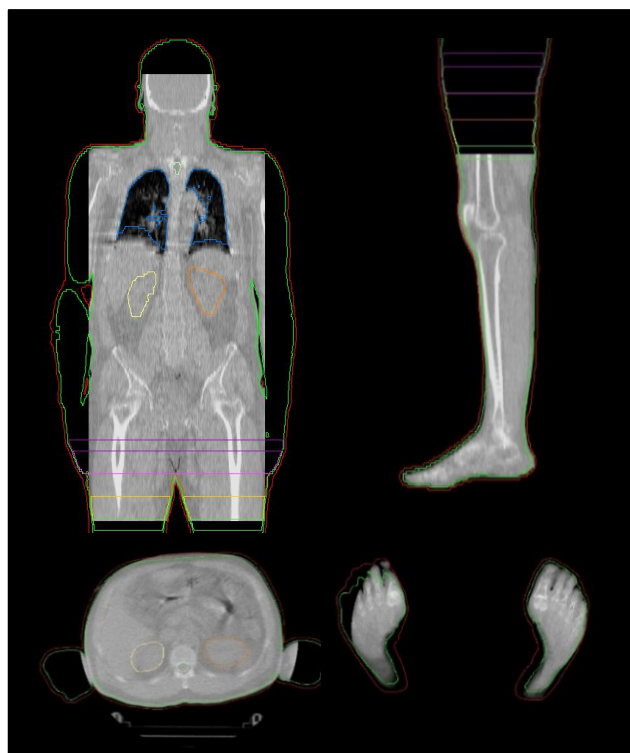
MVCT images from one patient showing good quality registration. It can be observed slight differences between treatment images (grayscale) and CT body contour (green line), but patient's body is still included at the IGRT_Body (red contour)
